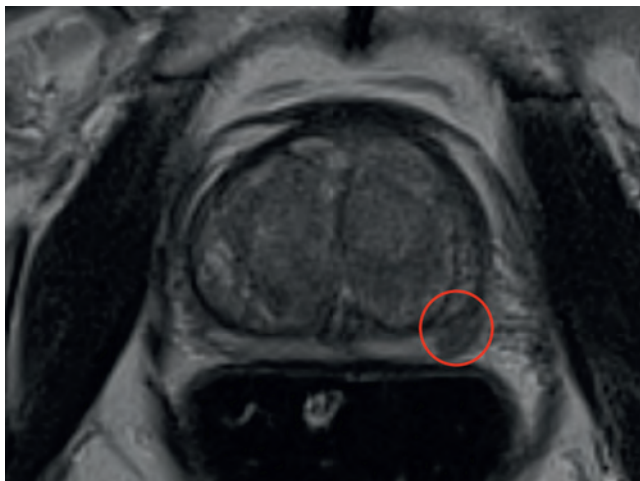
A 65-year-old man with prostate-specific antigen level of 6.5 who was found to have a lesion in the left peripheral zone on prebiopsy magnetic resonance imaging (MRI). This shows the T2-weighted MRI scan.
